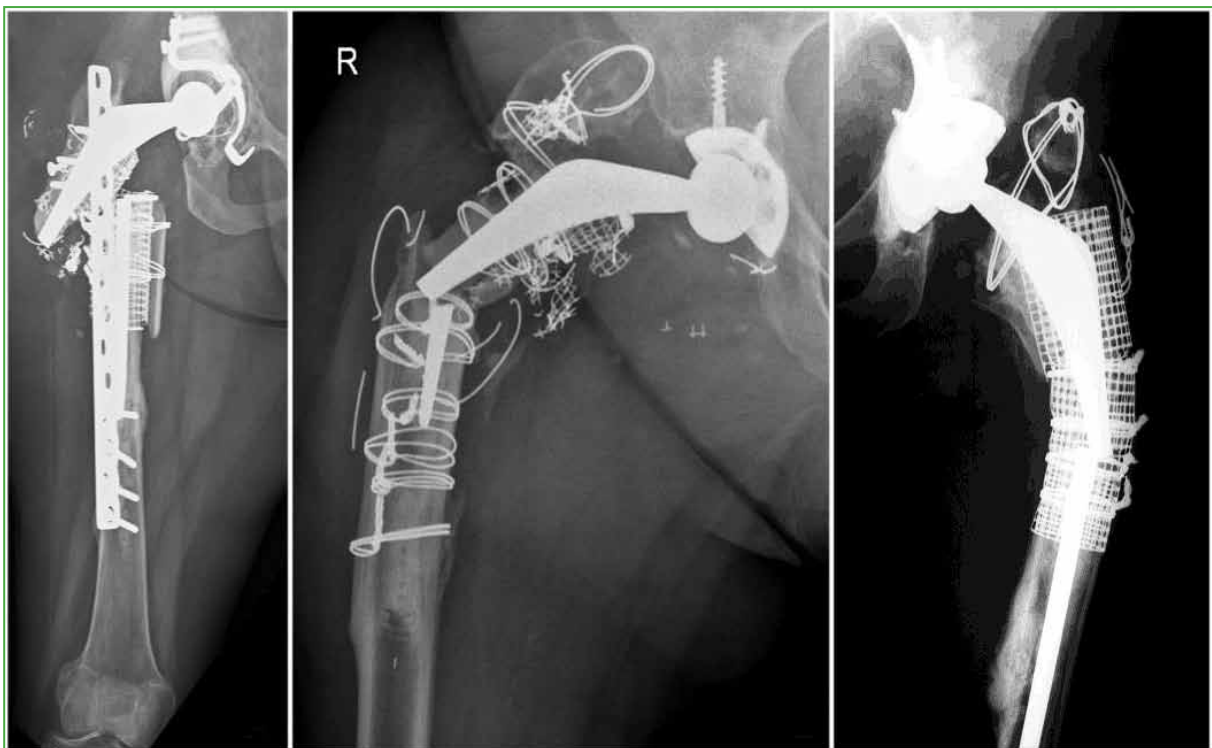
Preoperative anteroposterior radiographs of the femur and hip showing the three fractured C-Stems.
